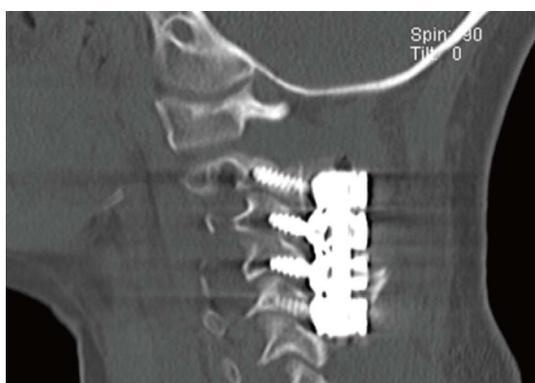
Sagittal computed tomography cut of a 5 year-old patient who underwent lateral mass screw fixation after tumor reconstruction.
